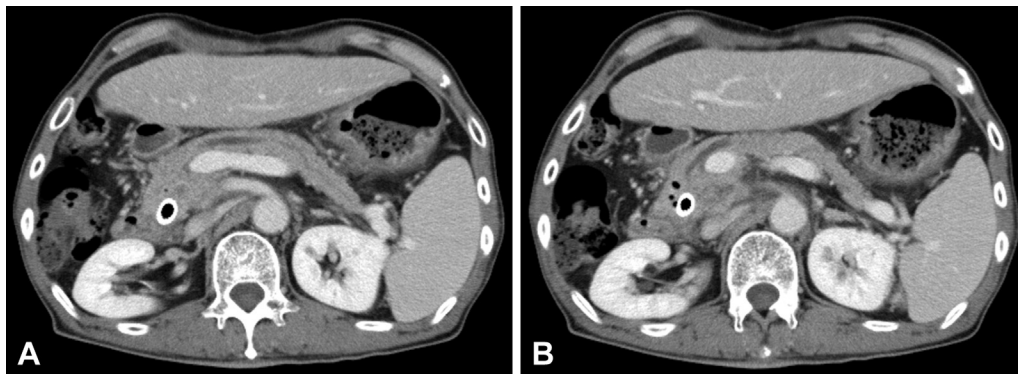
Abdominal CT reveals a main pancreatic duct stricture in the head of the pancreas and upstream ductal dilation.
